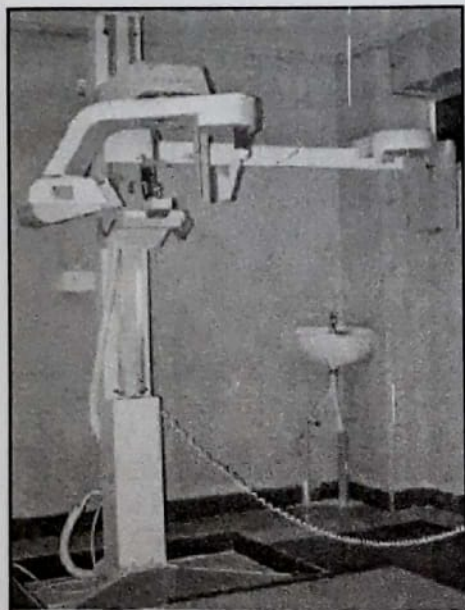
Rotagraph plus Panceph machine on which the PA ceph, lateral ceph and submentovertex view radiographs were taken.
